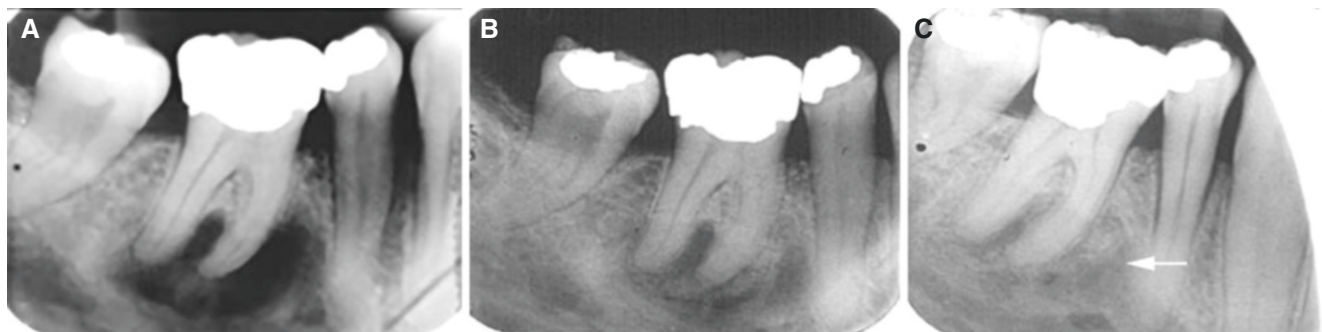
Focal osseous dysplasia, mandible; asymptomatic, vital tooth, with follow-up. Intraoral (periapical) views of molar, (A) baseline, (B) about 2 years later, and (C) about 4 years after baseline, show periapical radiolucency gradually becoming more mineralized (arrow)
